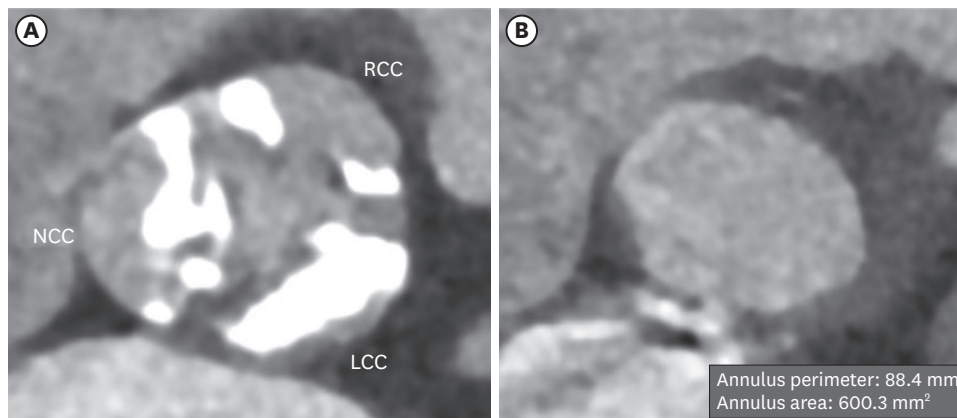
Computed tomography findings of aortic valve. Computed tomography showing heavily calcified leaflets at the sinus Valsalva level (A) and annulus measuring perimeter and area (B). LCC = left coronary cusp; NCC = non-coronary cusp; RCC = right coronary cusp.
